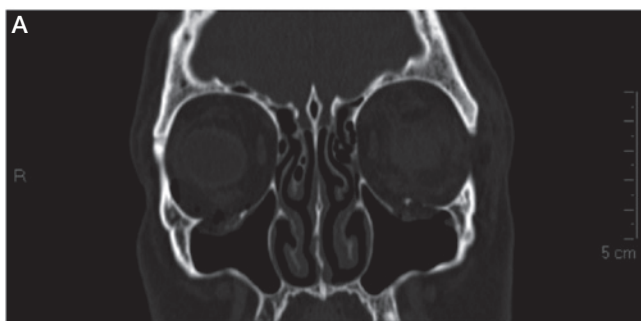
CT scans showing the displaced bilateral orbital floor fractures in the absence of other midface fractures.
